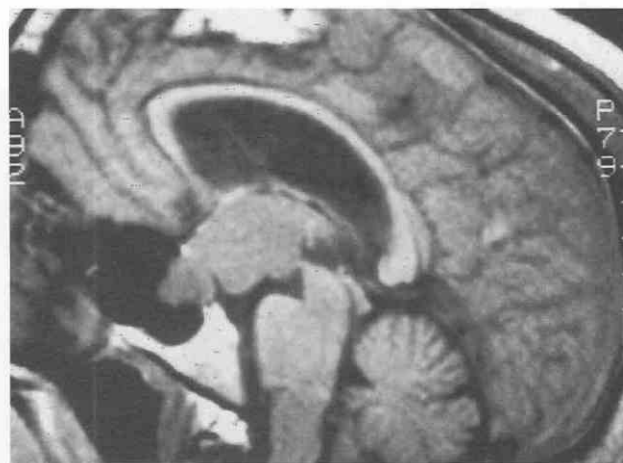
T1-weighted sagittal MRI study shows macroadenoma with suprasellar mass extension and superior displacement of the optic chiasm.
